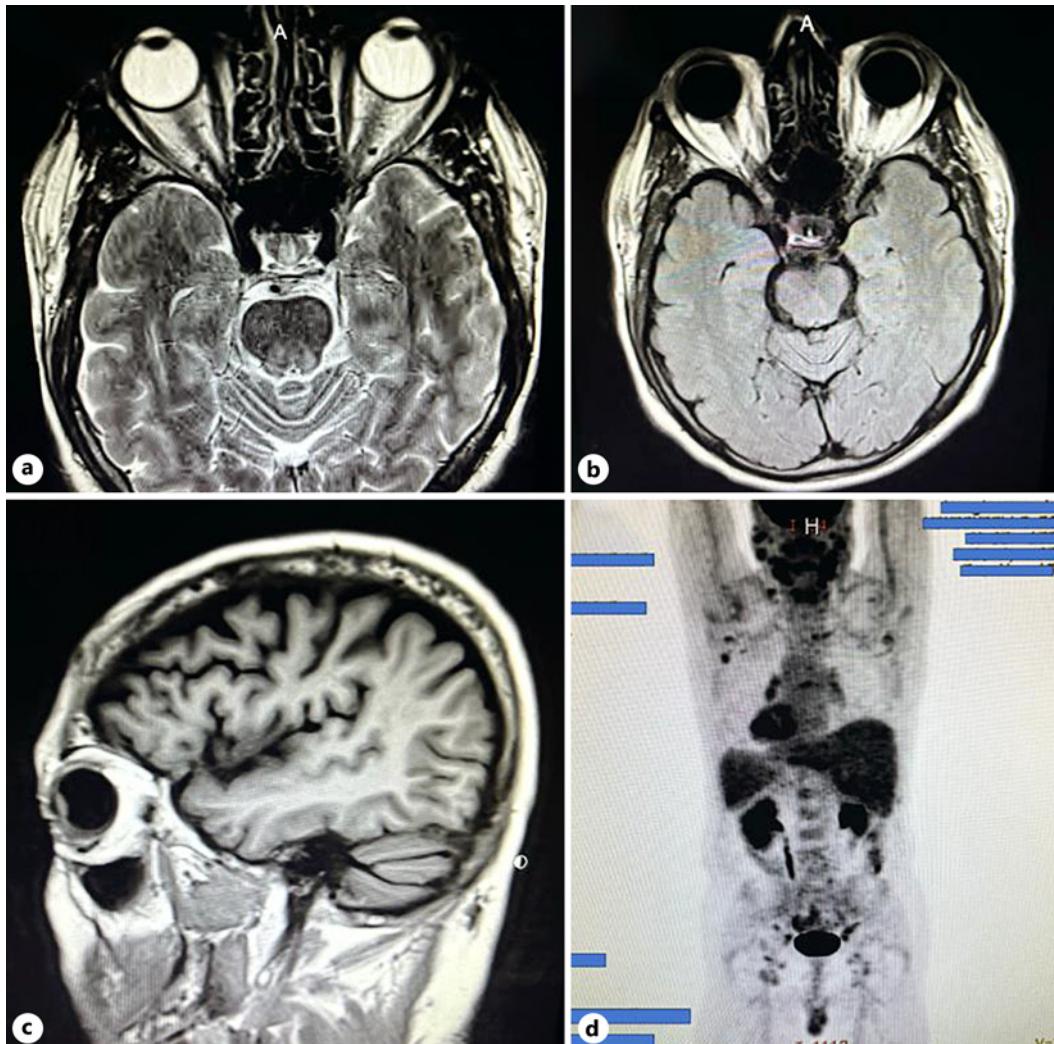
Magnetic resonance imaging (MRI) and positron emission tomography scan. MRI of the brain and orbits showing extensive marrow signal abnormality with no focal nodularity or mass in the orbit. a Axial T2 weighted image without contrast. b Axial T1 weighted image without contrast. c Sagittal T1 weighted image with 10 mL gadobutrol contrast. d PET scan showing bilateral cervical, mediastinal, axillary, inguinal lymph nodal, and splenic fluorodeoxyglucose uptake with maximum standardized uptake values ranging between 2 and 3.
